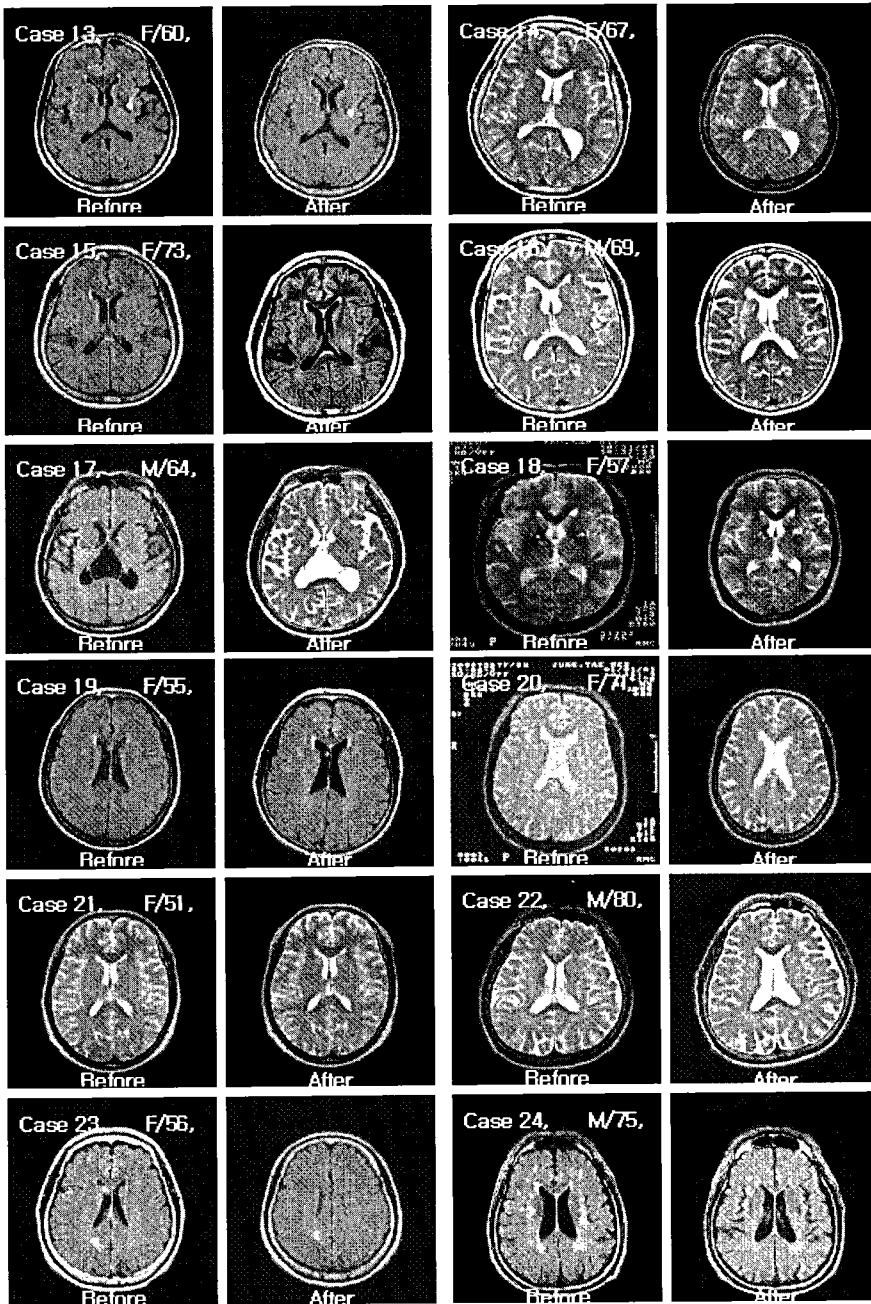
Brain MRI before and after 1 year of *Chunghyul-dan* medication in Cases 13 to 24
